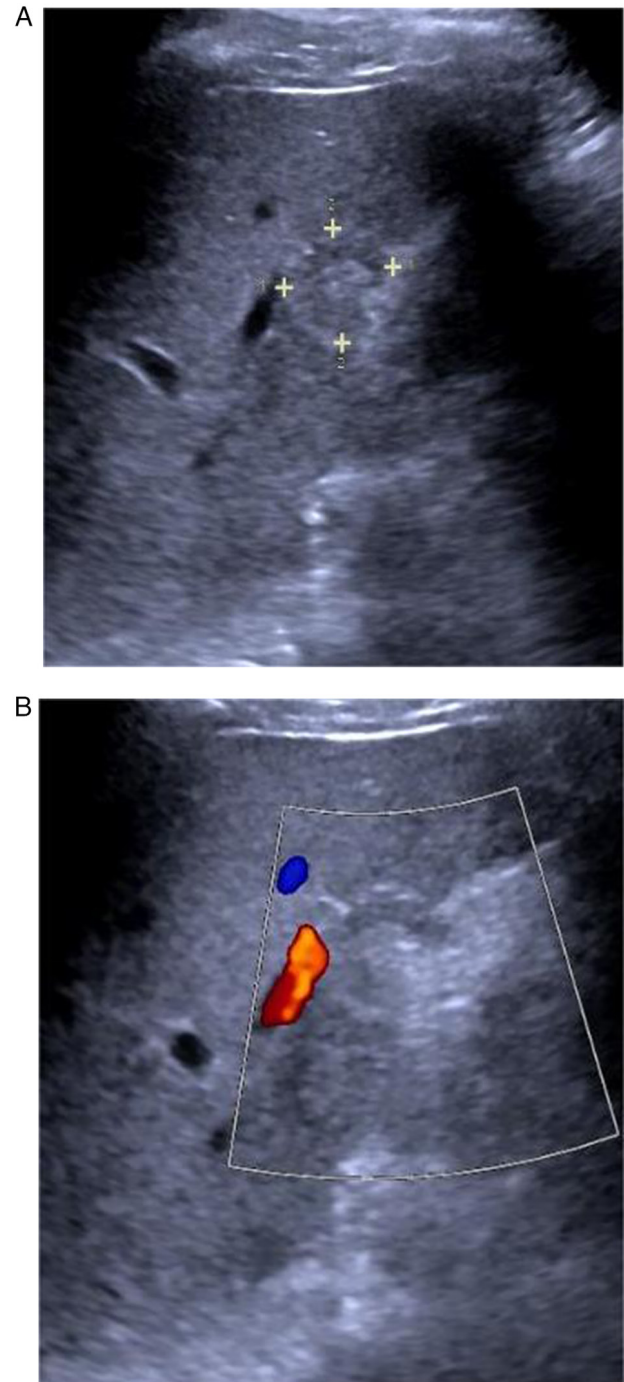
Two-dimensional ultrasound. (A) Hypoechoic nodule in the lower segment of the right anterior lobe of the liver (S5 segment). (B) No blood flow signal detected in the nodule.
